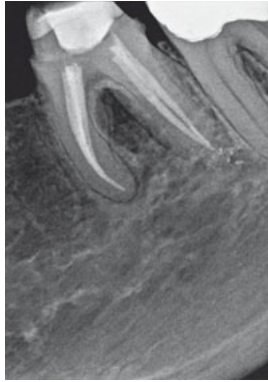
Control radiograph of the root canal filling in the orthoradial projection.
